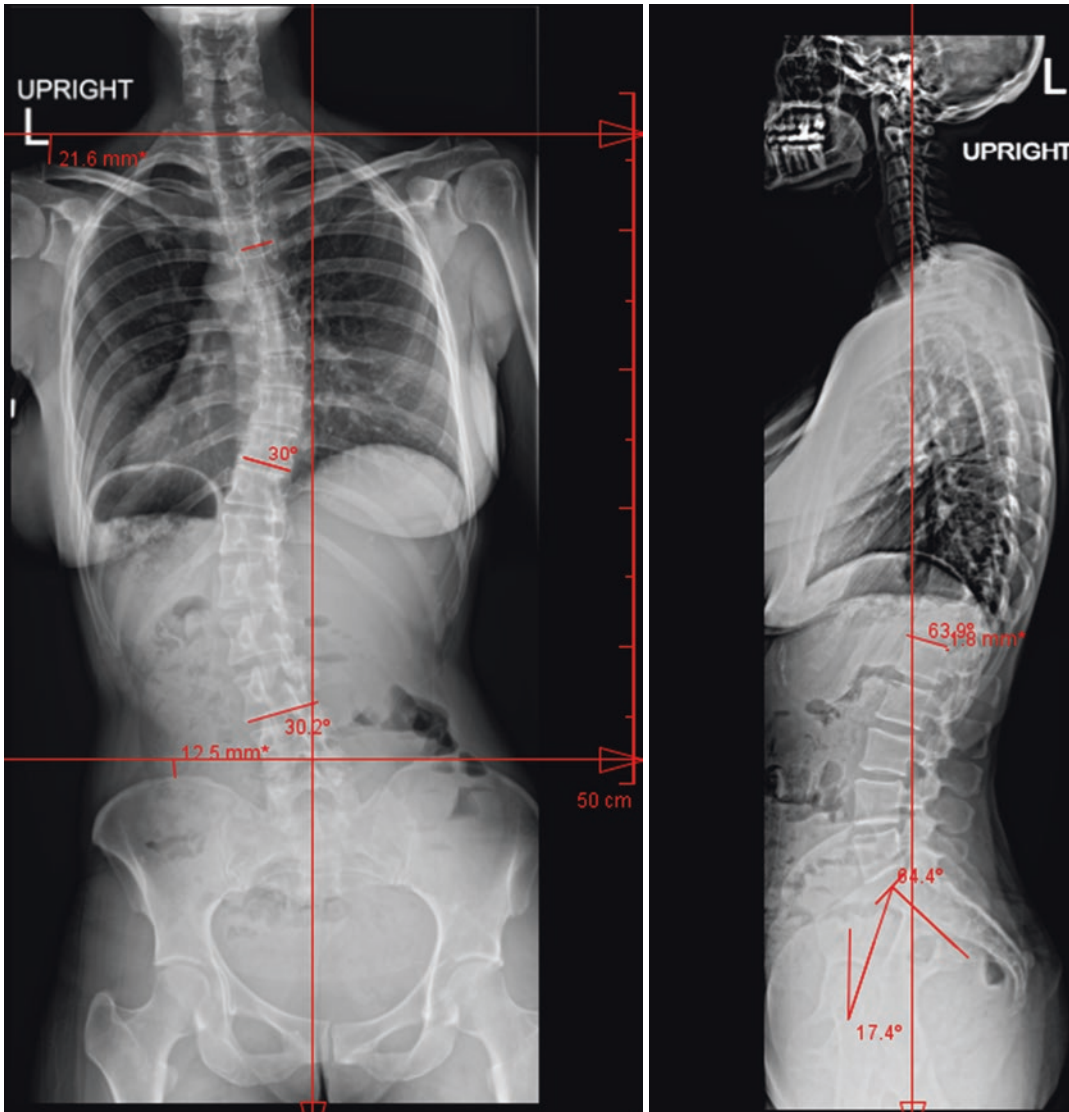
Preoperative AP and Lateral Scoliosis X-rays demonstrating coronal deformity and sagittal alignment assessment
